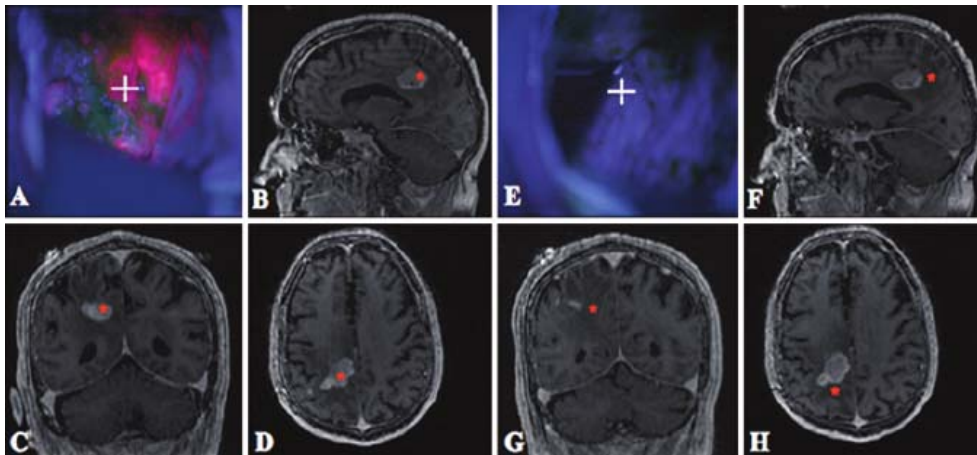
Malignant tumor parietal lobe. A) Intraoperative view pre-excision - it can be seen taking fluorescent substance by tumor tissue. B-D) MRI showing classic primary tumor mass. E) Intraoperative view of the surgical field after removal of glioma. F-H) post-neurosurgery MRI demonstrates macroscopic removal of the tumor mass.
